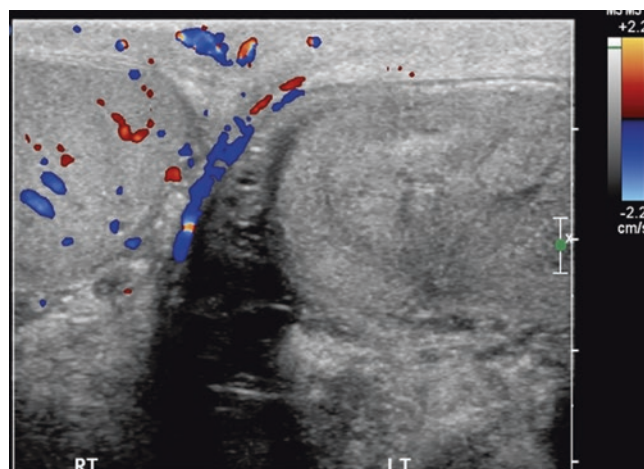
Scrotal Doppler ultrasound showing absent flow in the left testis consistent with testicular torsion. Note: normal color flow in the right testicle (left side of image)
